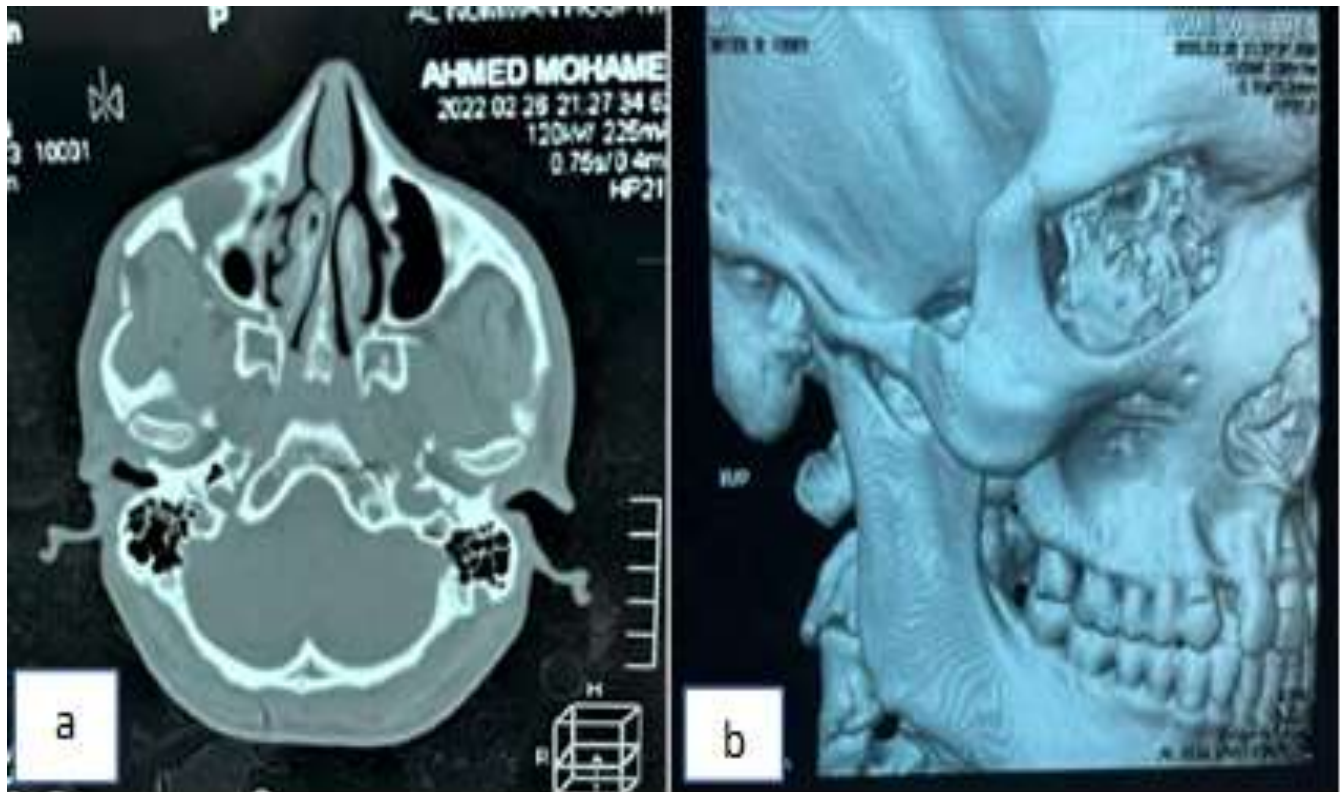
A: preoperative CT scan (axial view) showing right side zygomatic arch fracture. B: 3D views showing right side zygomatic arch fracture.
